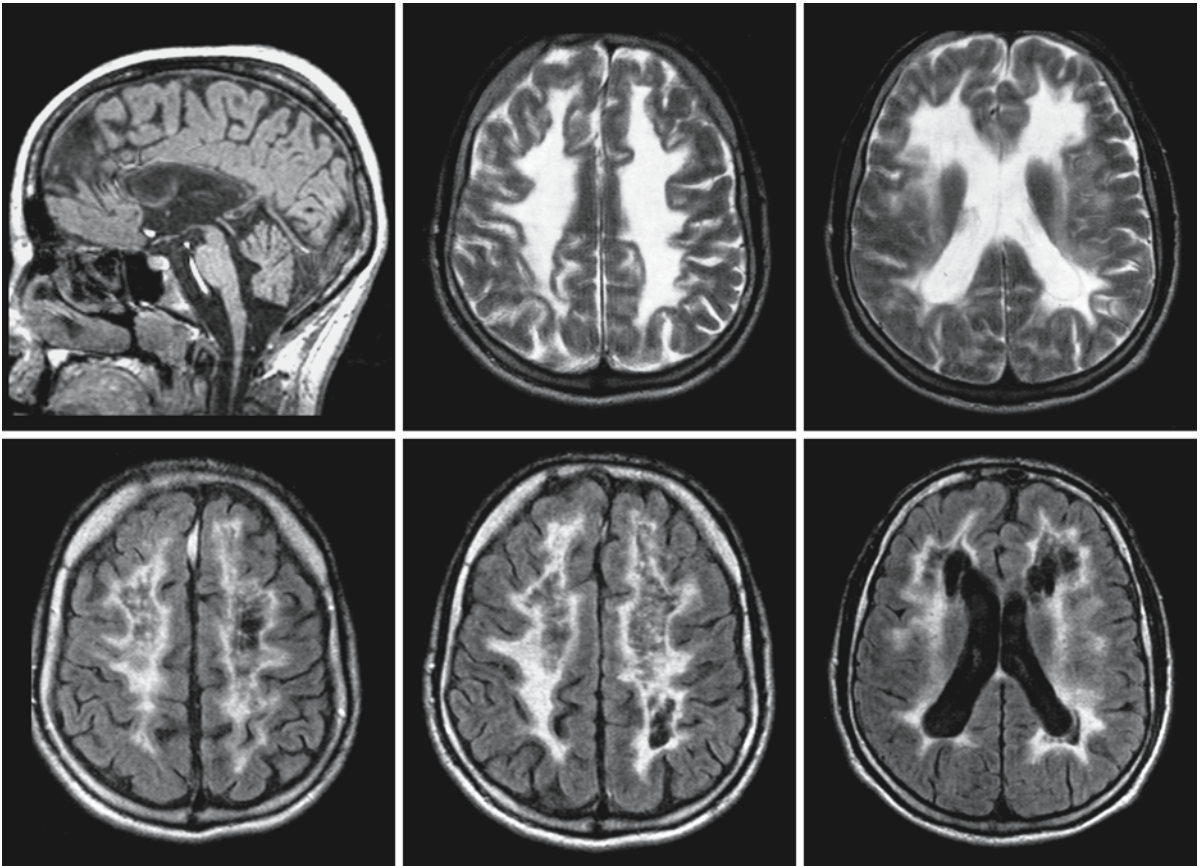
A 49-year-old man with a history of presenile dementia and motor problems. His MRI is typical for VWM and the diagnosis was DNA-confirmed. Note the thin corpus callosum. From Prass et al. (2001), with permission
